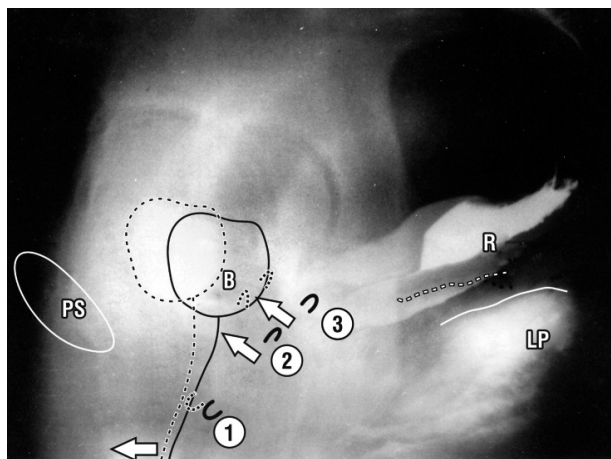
Squeezing xray superimposed on resting. Rest = unbroken lines; Squeeze = broken lines. Vascular clips at midurethra "1". Bladder neck "2" and bladder base "3". Radio-opaque dye in Foley balloon, vagina, rectum and levator plate. The muscle movements during 'squeezing' are upwards and forwards. Note how levator plate (LP) and rectum (R) are lifted upwards and forwards also. The only muscle which can do this is puborectalis, which lies below LP and behind R. B = Foley balloon. Note the difference with the movements in figure 3. Because 'squeezing', the basic Kegel exercise is not the natural mechanism, it must be learnt.
